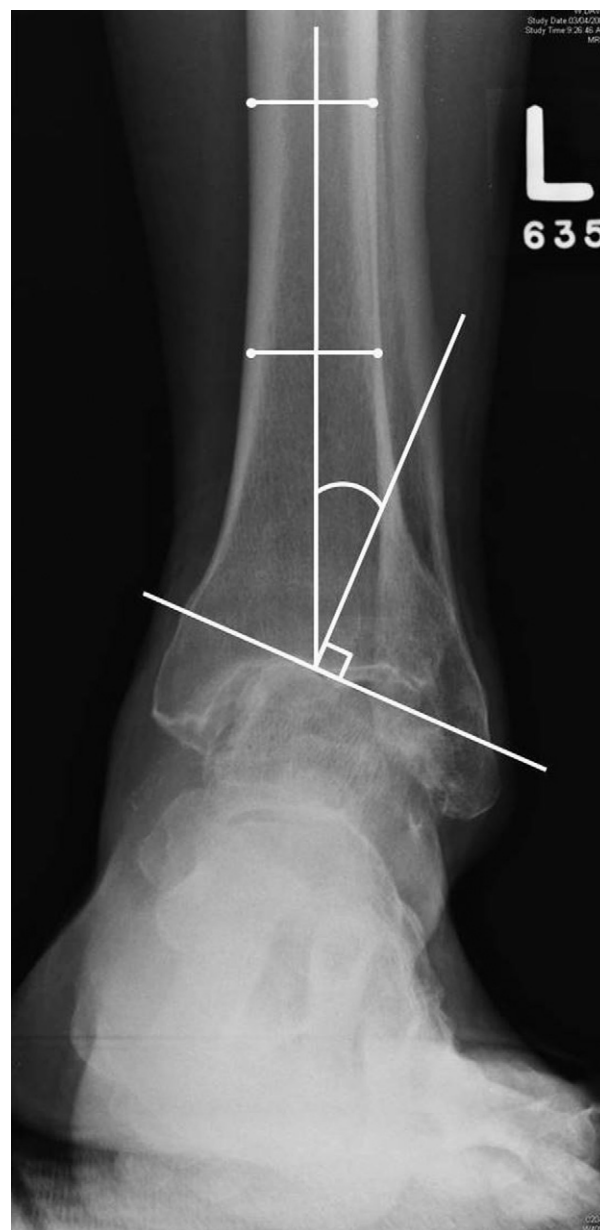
Example of the radiographic assessment to determine the coronal plane alignment.
